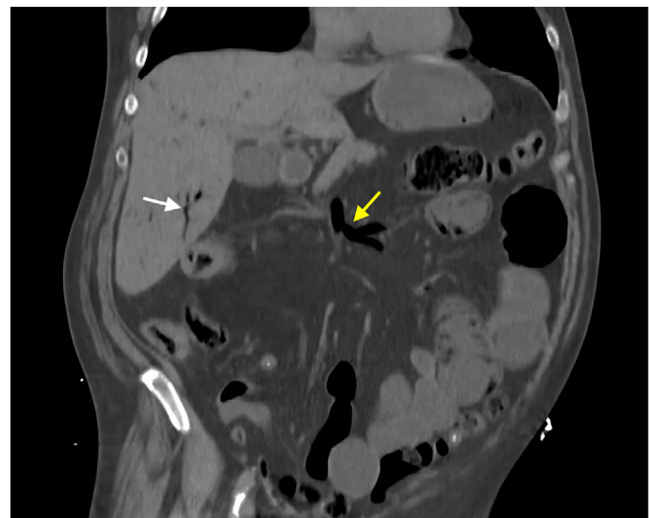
Abdominal computed tomography (CT) showing hepatic portal venous gas (A, white arrow). Gas is also seen within the superior mesenteric veins (B, yellow arrow)
